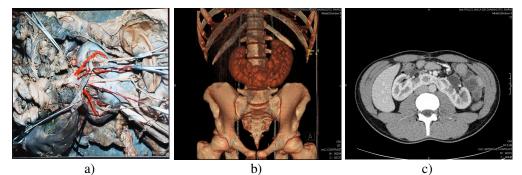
Horseshoe kidney: a) Horseshoe kidney, anterior position of the renal pelvis-dissection material b) CT exam - VRT reconstruction c) CT exam with contrast substance -axial section
